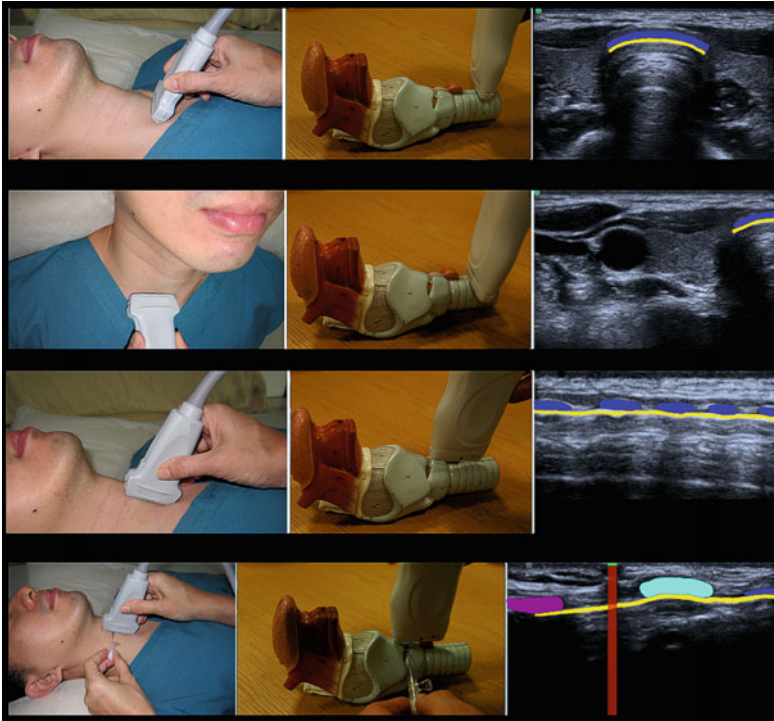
Longitudinal. Upper row: Step One; The patient is lying supine and the operator stands on the patient's right side facing the patient. The sternal bone and the suprasternal notch are palpated, which can be done in even the morbidly obese patient. The linear high frequency transducer is placed transversely over the neck just cranial to the suprasternal notch and the trachea is seen in the midline. The middle and the right photo show the ultrasound image and the relevant structures are highlighted on the photo to the right. Blue is the anterior part of a tracheal ring. Yellow indicates the tissue-air boundary inside the trachea. Everything below the tissue-air boundary is artefact. Second row: Step two; The transducer is slid laterally towards the patient's right side, until the midline of the trachea is at the right border of the transducer, and the corresponding ultrasound image of the trachea (in the right photo) is truncated into half. Blue is the anterior part of a tracheal ring. Yellows indicate the tissue-air boundary inside the trachea. Third row: Step three; Staying midline with the right edge of the transducer, the left edge of the transducer is rotated into the sagittal plane to obtain a longitudinal image of the trachea. The anterior part of the tracheal rings are appearing as black hypo-echoic round structures (like pearls) lying on a strong hyper-echoic white line which is the tissue-air boundary (that looks like a string). Hence, the image is akin to a "string of pearls". The blue markings represent the anterior parts of the tracheal rings. Yellow indicates the tissue-air boundary inside the trachea. Fourth row: Step four; The transducer is slid cephalad and the anterior part of the cricoid cartilage (turquoise) is seen as a slightly elongated structure that is significantly larger and more anterior than the tracheal rings (blue). Yellow indicates the tissue-air boundary inside the trachea. Immediately cephalad to the cricoid cartilage is the distal part of the cricothyroid membrane. The distal part of the thyroid cartilage (purple) is seen. Step five; the cricothyroid membrane can be pointed out by sliding a needle (used only as a marker) underneath the ultrasonography transducer from the cranial end until it casts a shadow (red line) just cranial to the cricoid cartilage (turquoise). The green spot represents the reflection from the needle. Care is taken not to touch the patient with the sharp tip of the needle. After this the transducer is removed, step six, and the needle indicates the level of the distal part of the cricothyroid membrane. This spot can be marked with a pen so that it remains easily located should it be needed for subsequent difficult airway management
